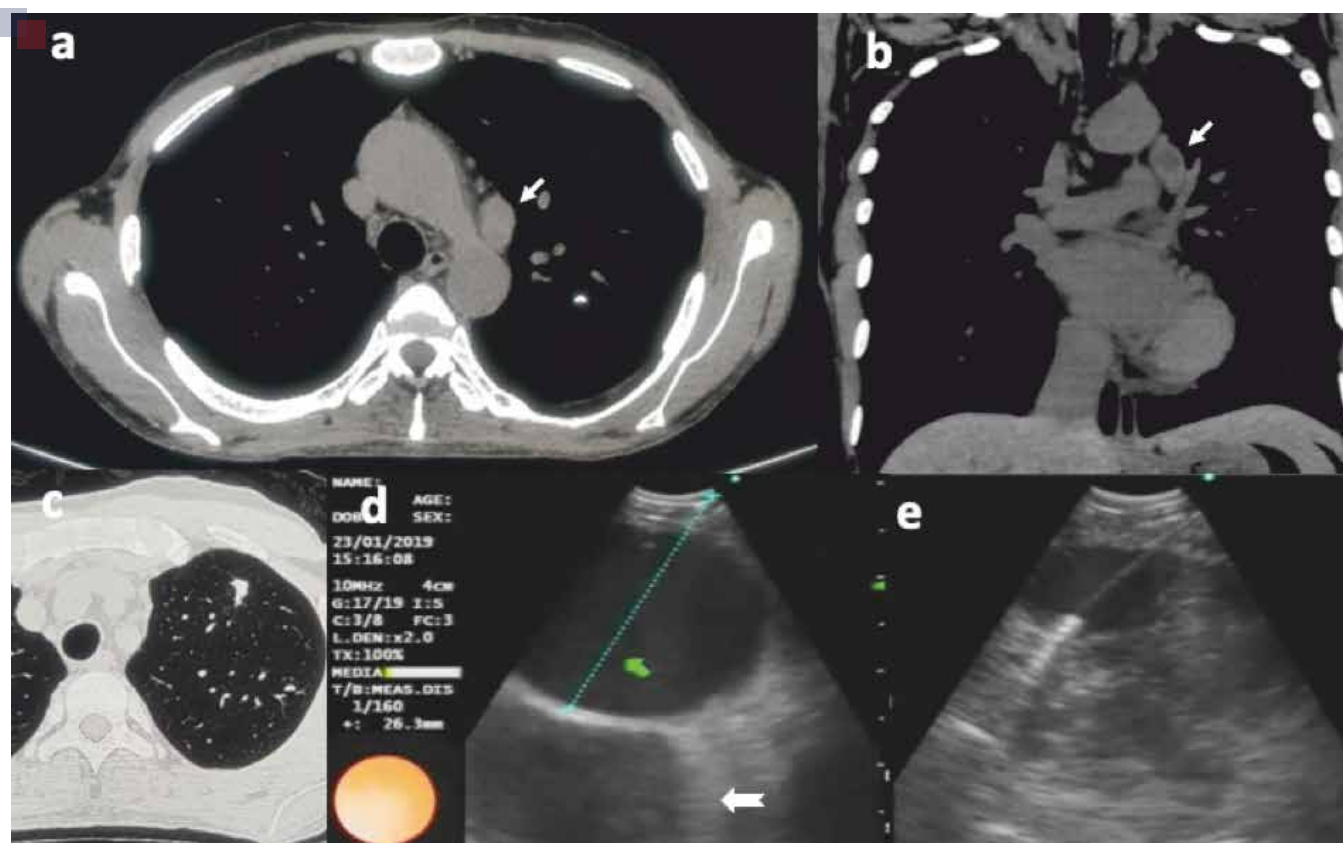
a-c) A non-contrast CT scan of the chest. 1a & b) Mediastinal windows in axial and coronal views reveal an enlarged lymph node (thin arrows) at the para-aortic location showing hypodense area within, suggestive of necrosis. 1c) Lung window in axial section showing a sub-pleural soft nodular lesion in the left apico-posterior segment. 1d) EBUS scanning along the left para-tracheal area shows a large lymph node (notched arrow) at a depth of 26.3 mm across the aorta at the station 6 location. The lymph node is oval in shape, has distinct margins, heterogeneous echogenicity and presence of coagulation necrosis. 1e) EBUS needle is seen passing through the aorta into the target lymph node at station 6.
